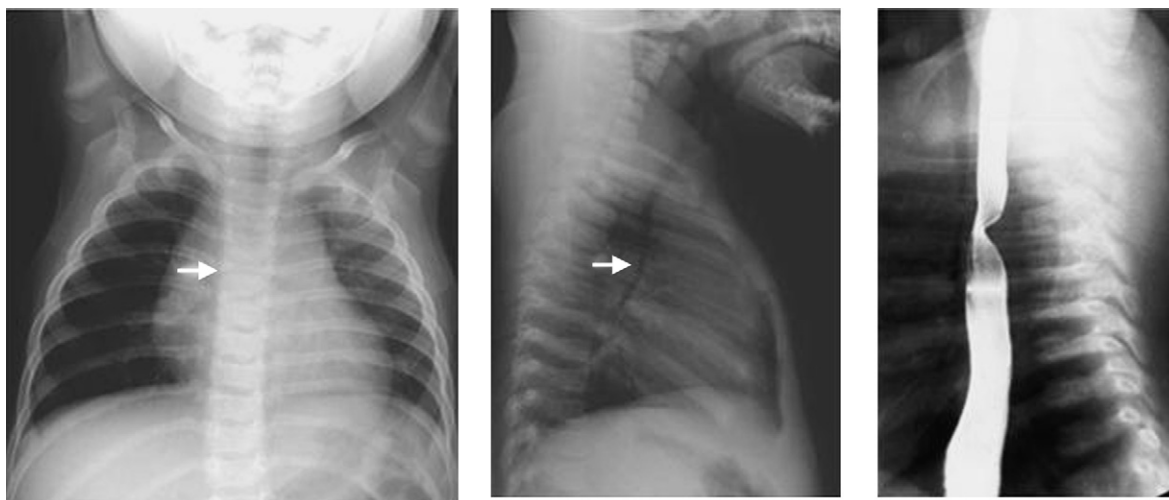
(Left) Anterior–posterior radiograph of the chest in child with a right aortic arch. *Note:* Displacement of the trachea towards the left indicating a right aortic arch. (Center) Lateral radiograph of the chest demonstrating narrowing and anterior displacement of the trachea by the aberrant left subclavian artery which passes behind it. (Right) Lateral esophagram showing posterior impression of the esophagus by the aberrant left subclavian artery.
